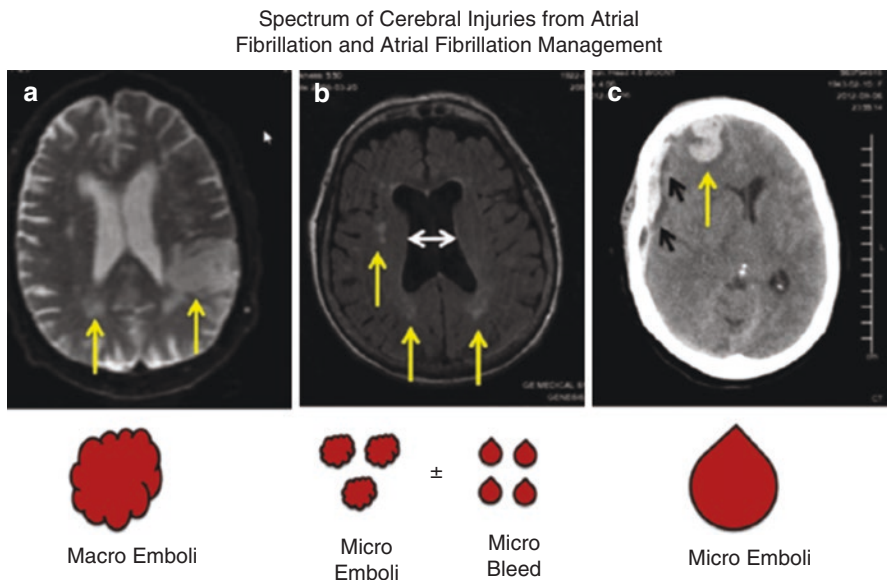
Three separate cranial images with the mechanisms that impact cognition that may be reduced with direct acting oral anticoagulants: (a) diffusion-weighted axial magnetic resonance images showing large ischemic injury in the left posterior parietal lobe. Multiple emboli are also seen; (b) axial magnetic resonance image in which the ventricles and cortical sulci demonstrate generalized atrophy and resultant enlargement in cerebral spinal fluid spaces as well as white matter disease; (c) non-contrast computed tomographic scan showing a subdural hematoma as well as intraparenchymal hemorrhage. Used with permission from Jacobs et al. (2015b). Jacobs V, Cutler MJ, Day JD, Bunch TJ. Atrial fibrillation and dementia. Trends in Cardiovascular Medicine. 2015;25(1):44–51
